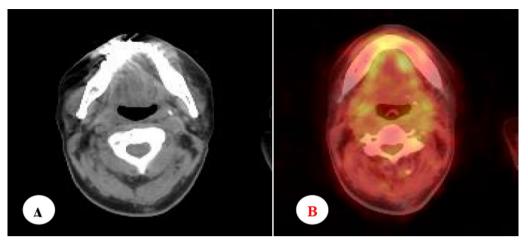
A male patient 52 year-old, a known case of undifferentiated carcinoma metastatic to the left cervical LNs, diagnosed in April 2012, underwent chemotherapy till March 2013 with disease remission as evidenced by PET/CT done outside our institution on 12/03/2013. In April 2014, he developed a nasopharyngeal soft tissue mass lesion, biopsy showed poorly differentiated keratinizing SCC; accordingly, he was subjected to chemo and radiotherapy. PET/CT done in 2021 showed (A) Axial CT image, (B) Axial PET/CT image showed no scintigraphic evidence of any foci of increased tracer utilization at the head and neck region, denoting total resolution of the tumor after CRT. According to NI-RADS Template, its score is NI-RADS (I). No biopsy was done (not indicated). Follow-up PET/CT was advisable
